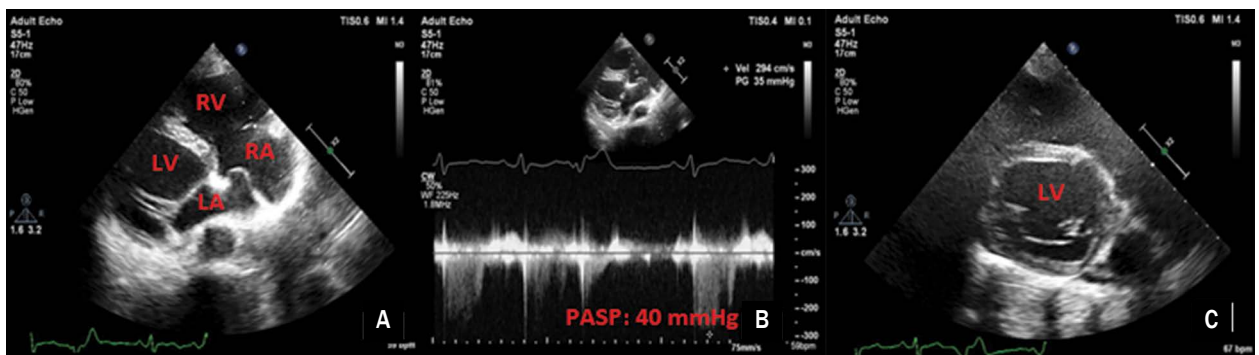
Transthoracic echocardiography; parasternal long axis: A. Right heart chambers were dilated. The interatrial septum was thin and aneurysmatic; B. Pulmonary arterial systolic pressure (PASP): 40 mm Hg; C. The left pulmonary vein and arteries could not have been seen; LA – left atrium; LV – left ventricle; RA – right atrium; RV – right ventricle
